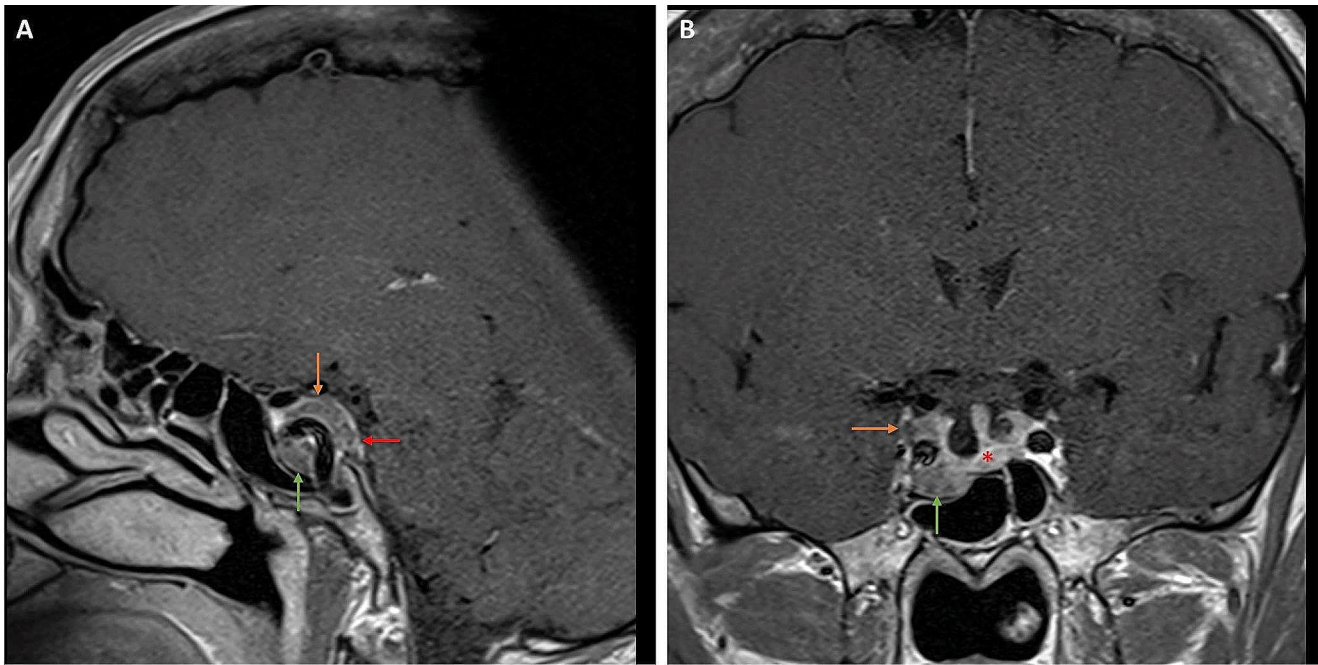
Case involving a 62-year-old patient with abnormal IGF levels (745 $\mu\text{g/L}$) and acromegalic features. (A and B) Pre-operative Gd-enhanced T1W sagittal and coronal MR images showing a pituitary macroadenoma invading the inferior (green arrow), medial, superior
